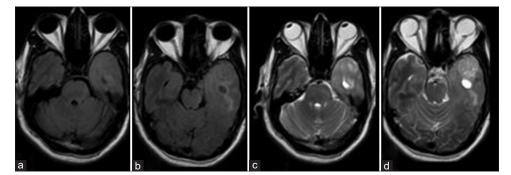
Sequential axial FLAIR (a and b) and T2-weighted (c and d) MRI done at the time of initial presentation showing multiple ill-defined area of high signal intensity involving the left temporal lobe FLAIR = Fluid-attenuated inversion recovery; MRI = Magnetic resonance imaging
